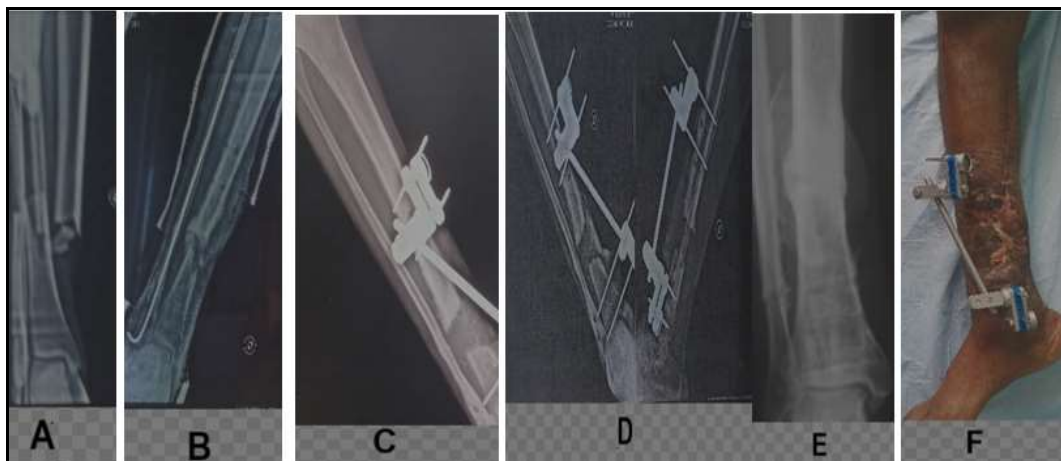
a 49-year-old man with septic pseudarthrosis of the right leg. A: initial x-ray of the tibia, frontal view. B: leg x-ray at the time of diagnosis of hypertrophic septic pseudarthrosis, frontal view. C: 1st stage of Papineau. D: 2nd stage of Papineau. E: bony consolidation of pseudarthrosis. F: Wound healing
